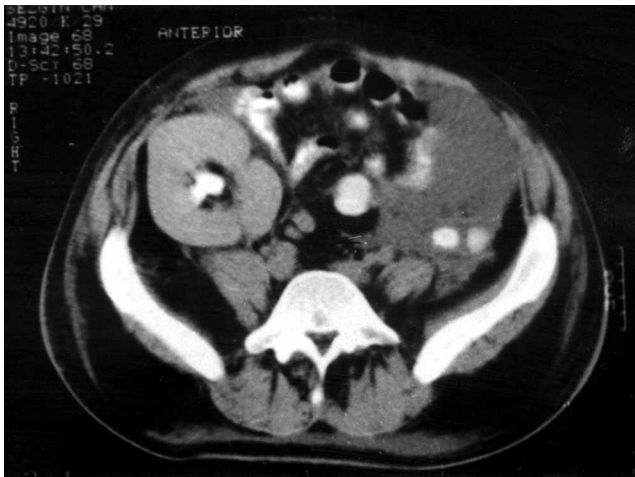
CT shows ascites plus the renal graft in the right iliac fossa.
